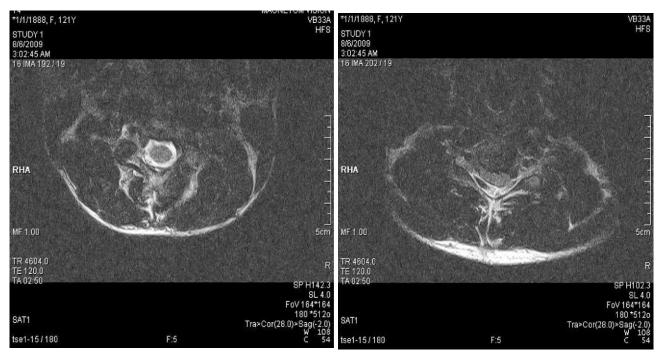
T2 axial MRI shows cord thinning in neutral position.
